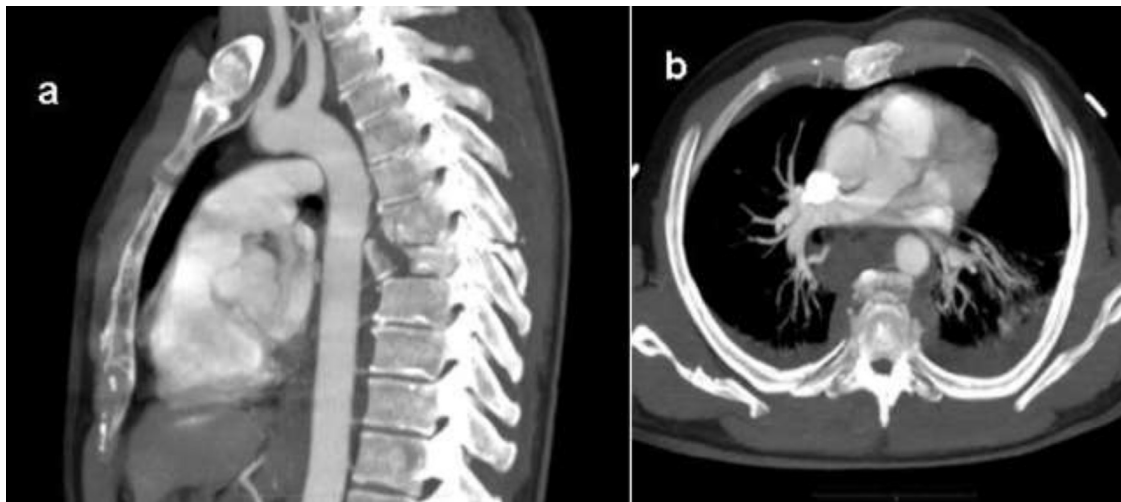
Sagittal (a) and axial (b) CT-angiography: compression/distraction fracture of 6th and 7th dorsal vertebrae. A bone fragment is encroaching on the descending thoracic aorta although without signs of wall disruption (i.e. absent peri-vascular contrast leakage). A 3-D volume rendering reconstruction (c) confirms integrity of the aortic walls.
